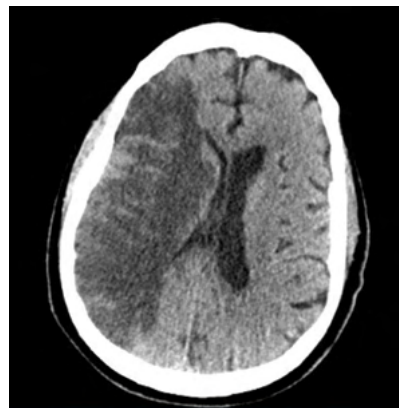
CT brain with large right MCA infarct with edema and mass effect.
